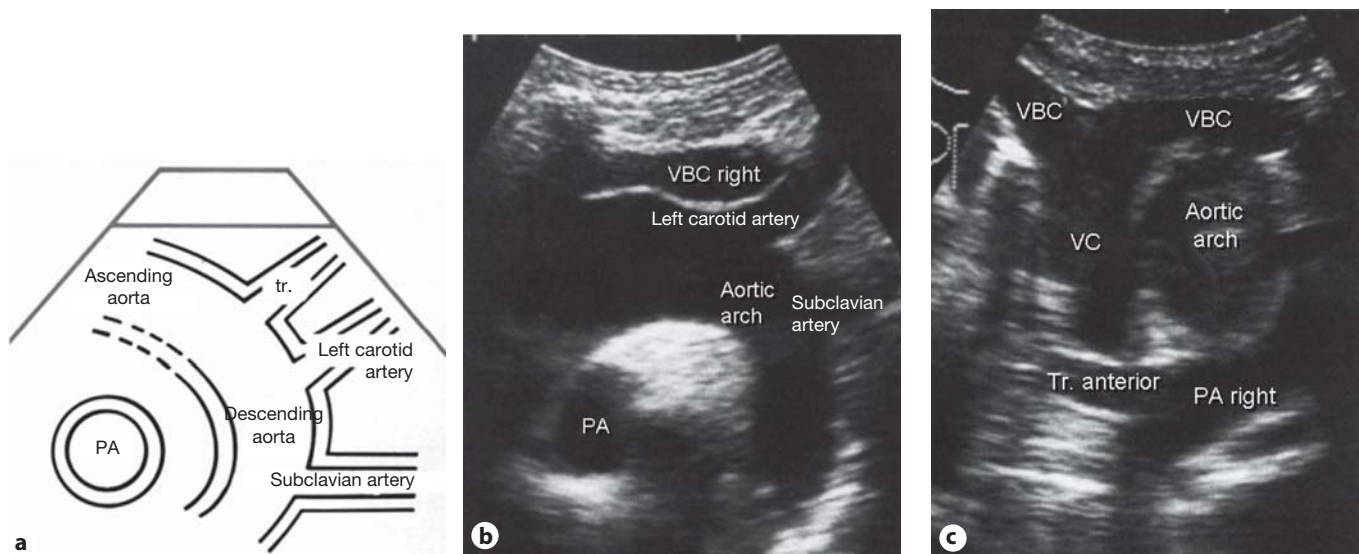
Suprasternal ultrasound in the supine position; by moving the probe in different directions an adequate acoustic window can be obtained.
